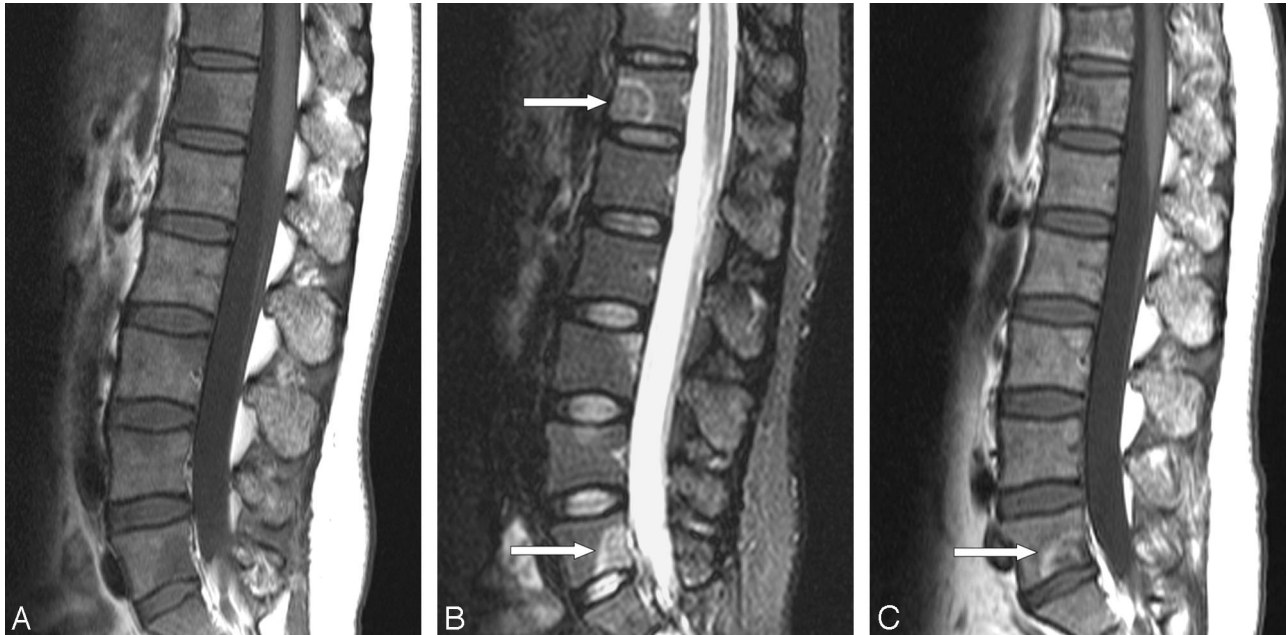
A 46-year-old woman with fever for 2 days. *A* and *B*, Sagittal T1-weighted (TR/TE, 550/12) (*A*) and sagittal STIR (TR/TE/TI, 3130/65/160) (*B*) MR images show multiple intraosseous lesions of T1-weighted low signal intensity and STIR high signal intensity. Note some osseous lesions with a positive halo sign (arrows) and the absence of paraspinal or epidural inflammatory soft tissue. *C*, Sagittal T1-weighted (TR/TE, 550/12) follow-up MR image obtained 12 months later shows gradually reconstituted fatty marrow with a decrease in the number and extent of infectious foci. Note a peripheral rim of increased signal intensity (arrow) in a residual subchondral lesion of low signal intensity at the lower endplate of L5.
